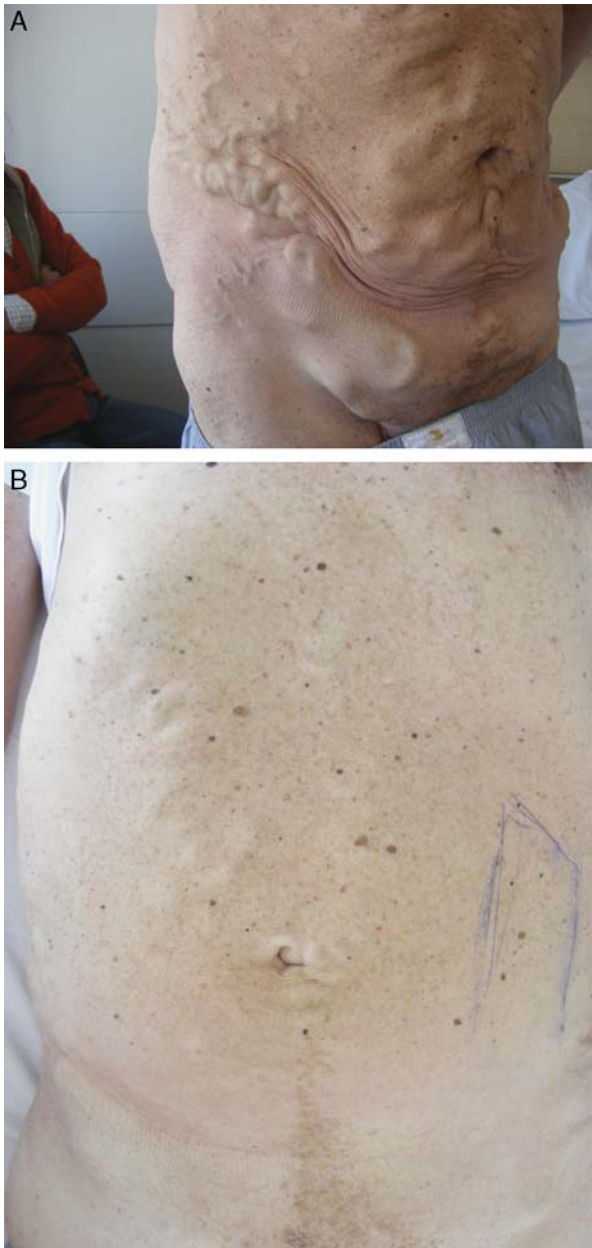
Patient with extensive subcutaneous venous collaterals in the abdominal wall (A). Marked area free of collaterals, determined by duplex sonography vein mapping (B).
